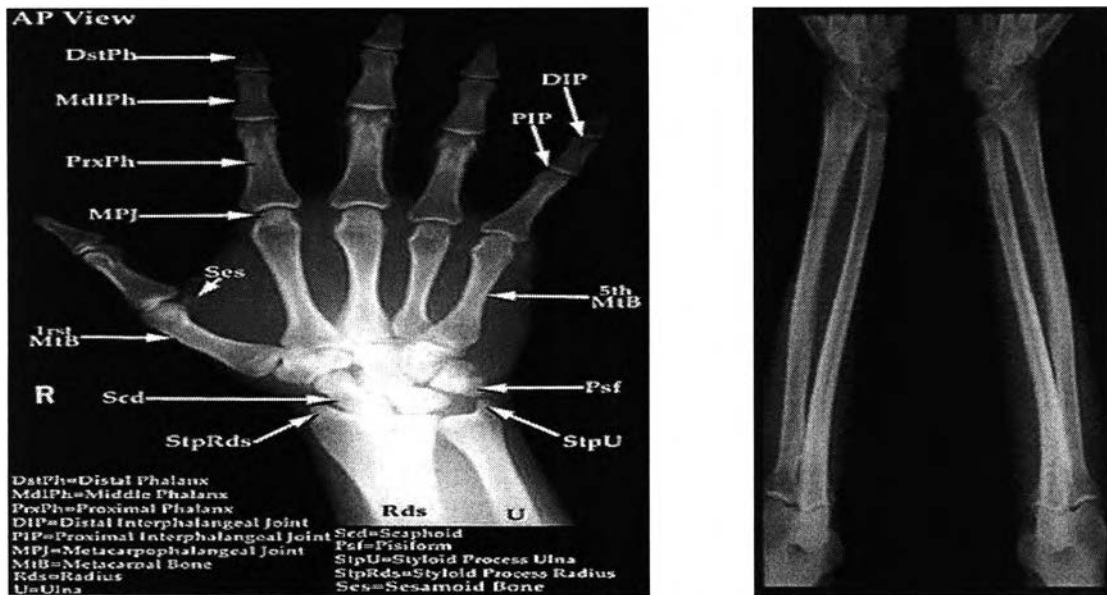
Arm radiographs of normal and MDK patient. Upper row; normal hand and arm. Lower row; right arms of patient at (a) age 8 and (b) 21 years. Left arms at (c) age 8 and (d) age 21 years. Note progressively bowed radii, large distal humeri, and overlapped carpal bones. Flexion contracture of the distal interphalangeal joints of 4 and 5 on both sides.
